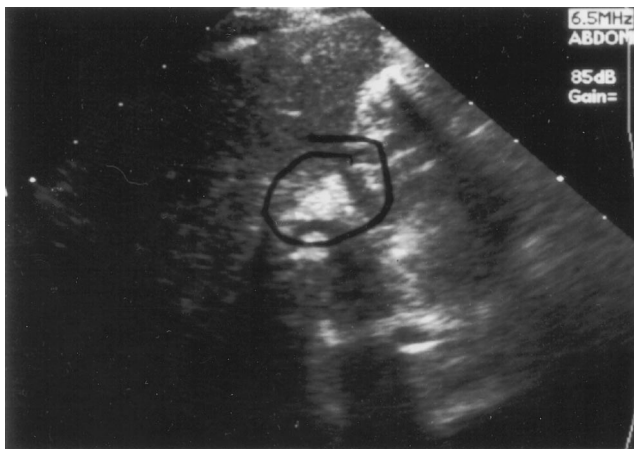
Longitudinal ultrasonogram showing the TC sign (circled) cranial to the portal vein in a patient with biliary atresia.
